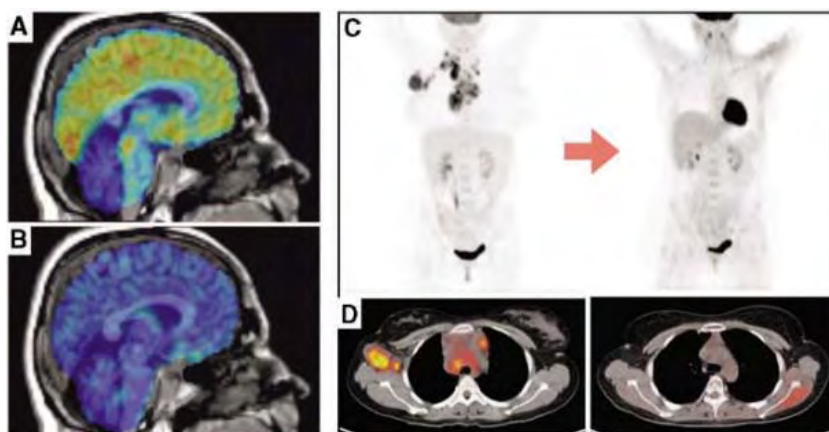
Molecular imaging used for monitoring of patient response to therapy. (A) PET scan of brain substance P (neurokinin-1 receptor) using ^{18}F -substance-P antagonist-receptor quantifier (SPA-RQ) superimposed onto an MRI scan. (B) PET scan after receptor blockade with Aprepitant, a neurokinin-1 receptor antagonist. Blue indicates low levels of tracer binding; yellow and orange indicate high levels of tracer binding. The study shown here assessed the efficacy of Aprepitant as a treatment for depression; however, the drug is also used to treat cancer patients for chemotherapy-induced nausea. Panels (A) and (B) are reprinted with permission from (42) with permission from the Society of Biological Psychiatry. (C) FDG-PET scan of a patient with lymphoma before (left) and after (right) treatment. (D) Corresponding axial PET-CT axial sections show a decrease in FDG activity (yellow red) in axilla and mediastinum.
